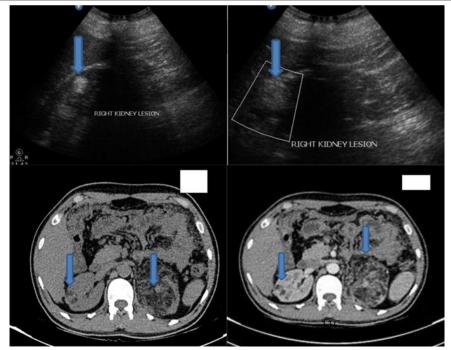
Angiomyolipoma: well-defined hyper-echoic lesion in upper pole of right kidney. On color Doppler, no internal vascularity is seen. NECT and CECT scan showing heterogeneously enhancing lesions in both kidneys with fat density areas within them.
